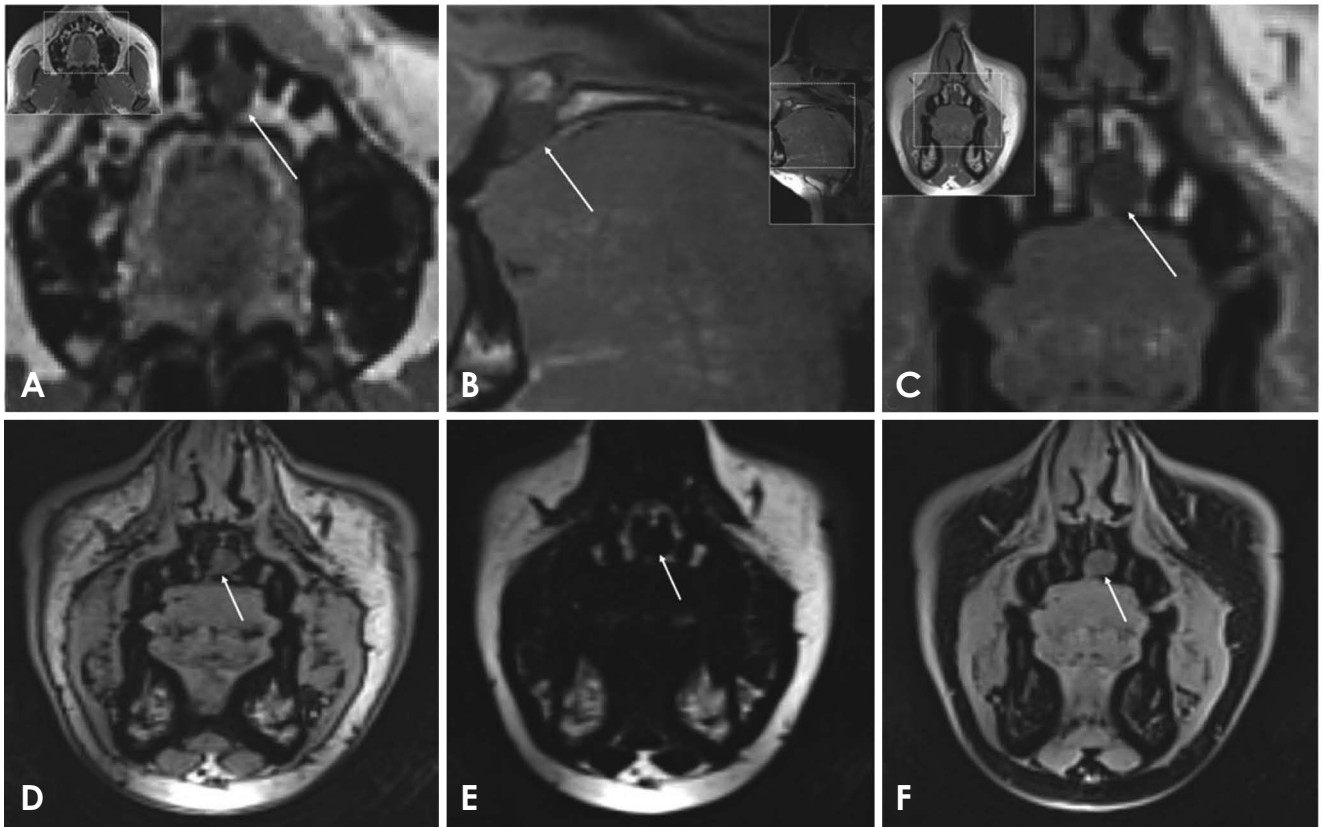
Magnetic resonance imaging with the T2-weighted DESS (A-C), STIR (D-F), and SPAIR (G-I) sequences reveal a well-demarcated homogeneous high-signal-intensity lesion (nasopalatine duct cyst) between and posterior to the right and left central incisors, without infiltration of adjacent anatomical structures.
